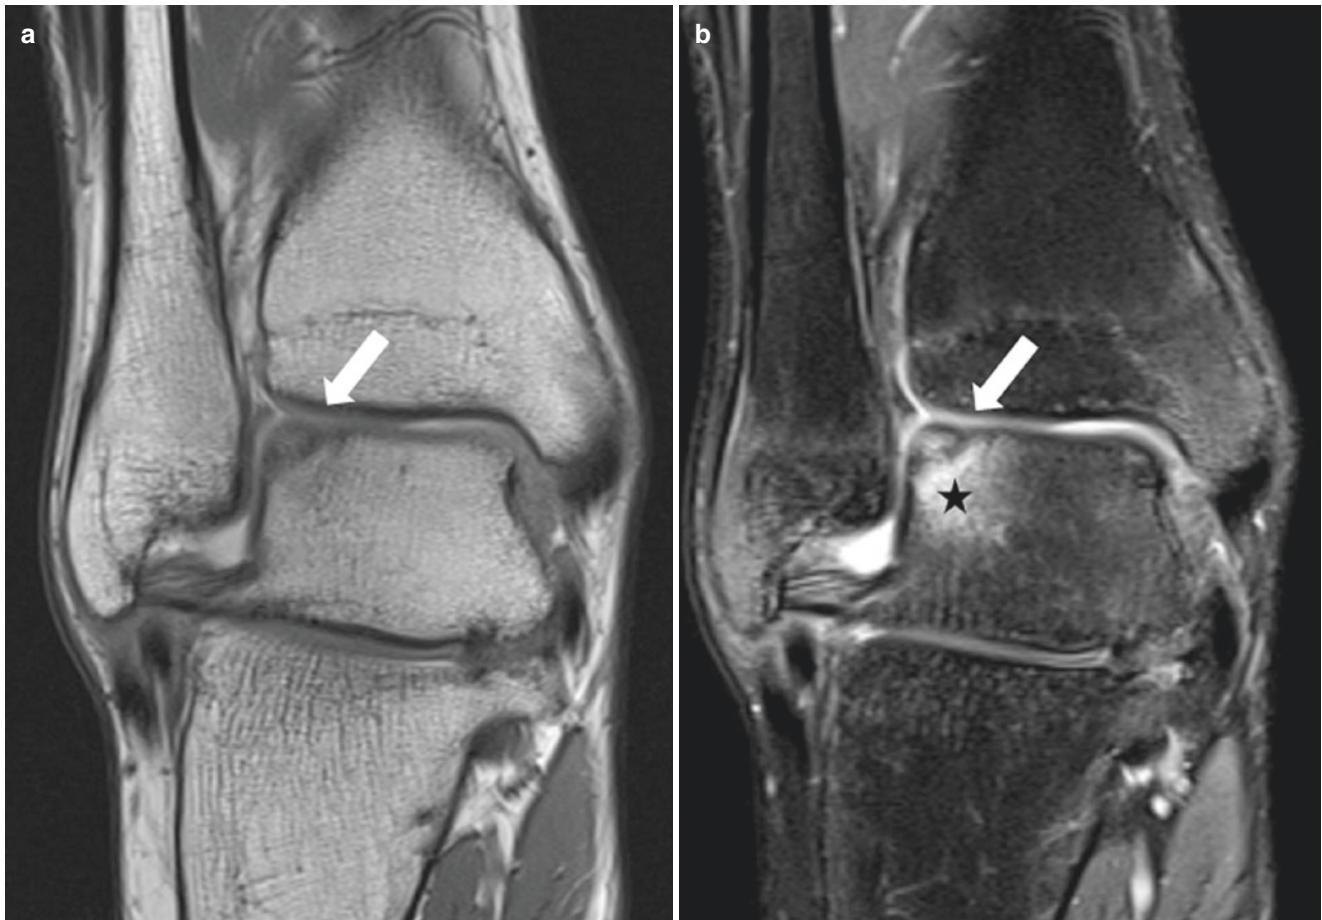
Osteochondral lesion (OCL) of the talus. Coronal T1-weighted MR image with DRIVE pulse (a) and corresponding fat-suppressed intermediate weighted image (b) obtained eight weeks after
